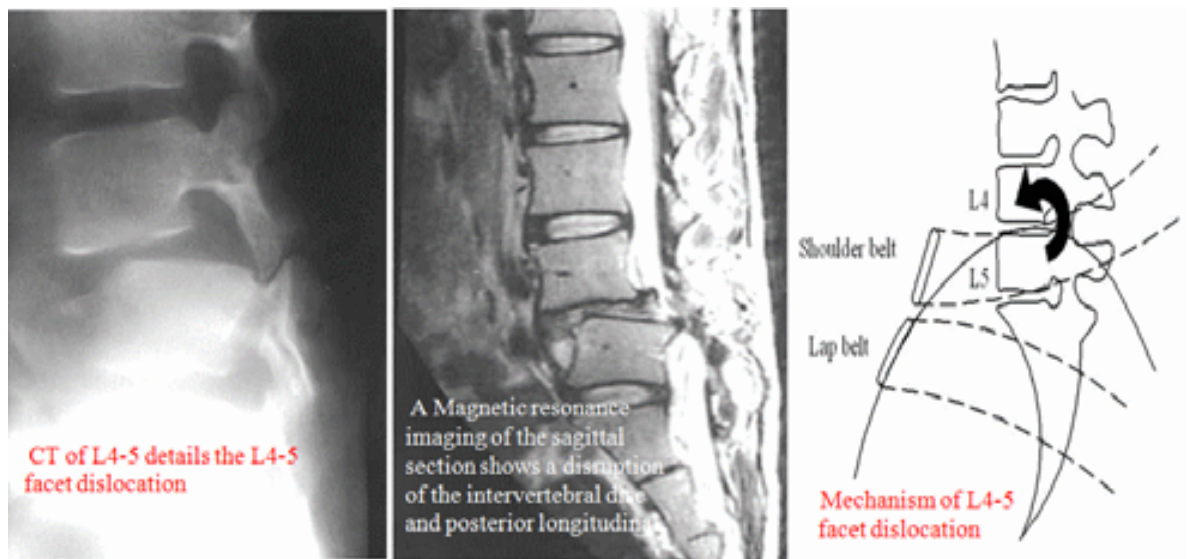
Radiographic images of spinal injuries for driver in Case 4
